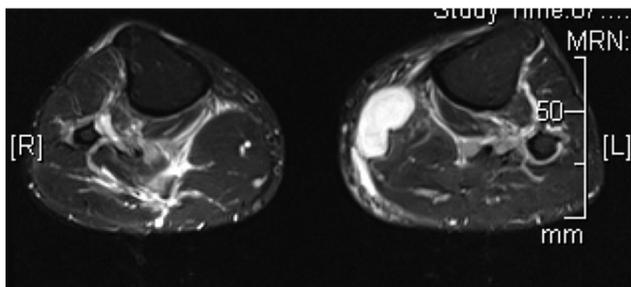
Thigh muscle magnetic resonance imaging (MRI): the T2-sequence shows increased signal intensity within deep fascial layer predominantly in the right thigh.
